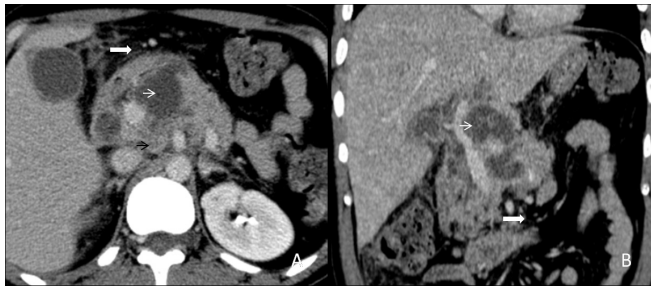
(A,B) A 30 years old male patient with constant and chronic vague pain in the epigastric region undergone a contrast-enhanced computed tomography of abdomen. The axial and reformatted coronal plane images from the venous phase show a bulky pancreas having intraparenchymal collections (white arrows), peripancreatic fat stranding (thick white arrows) and enlarged lymph nodes (black arrow). It was later diagnosed as pancreatic tuberculosis on fine-needle aspiration from the cystic component. Standard antituberculous therapy involving at least four drugs remains the cornerstone of the treatment. Therefore, the patient has been on ATT for the last three months.
